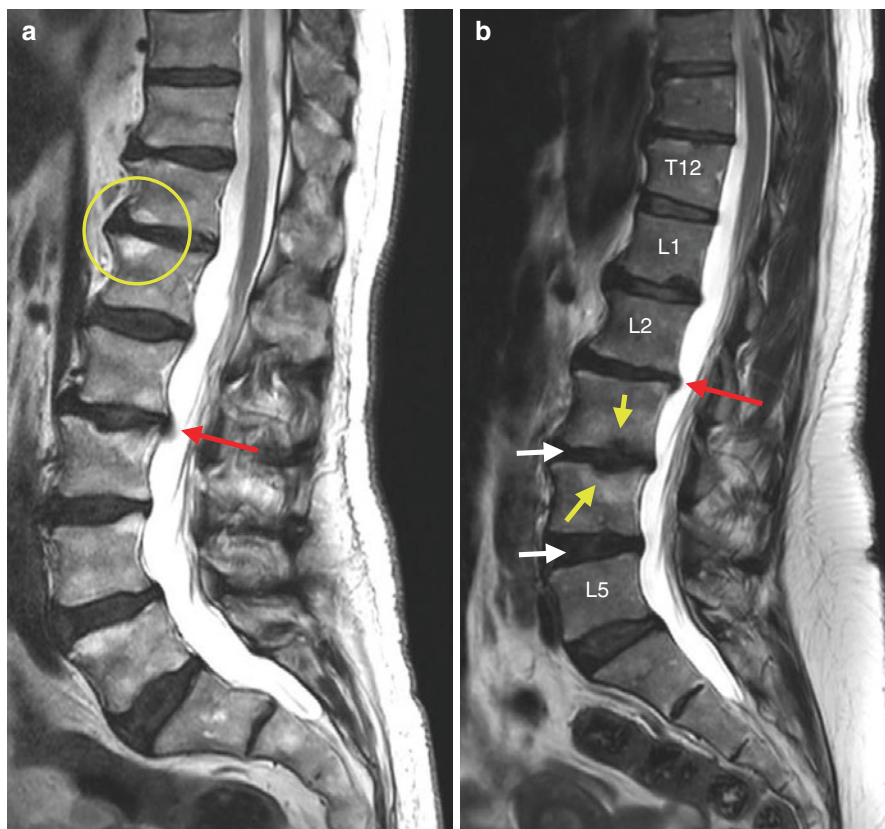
MRI of the lumbar spine in osteoarthritis.
